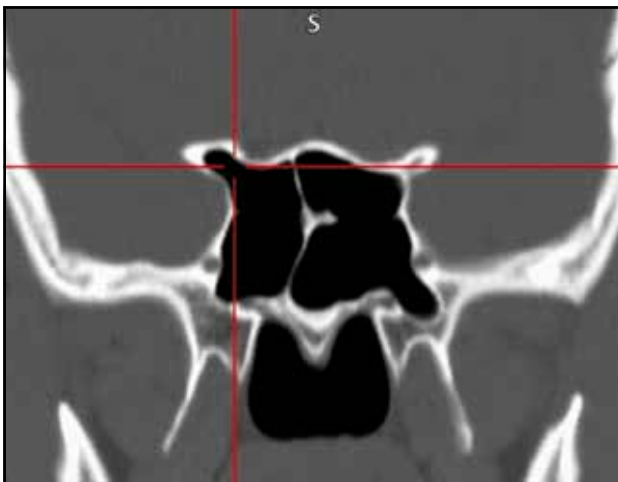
Lesser wing extension (right sphenoid sinus) (cranio-facial CT scan, coronal slice).
